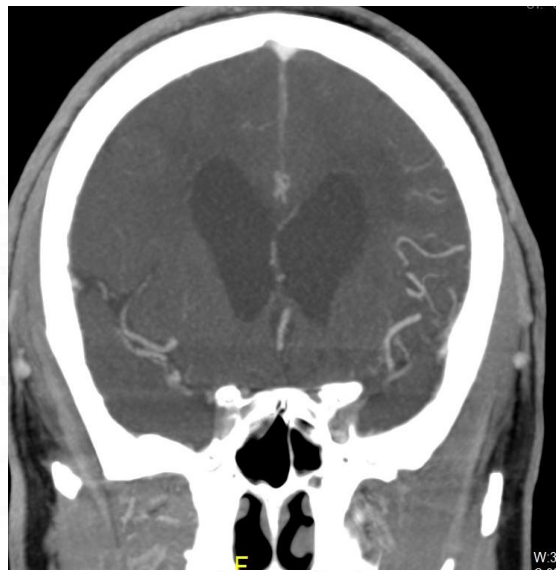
Coronal CT MIP Art. del. phase showing good col. score (mASITN/SIR grade 4)
